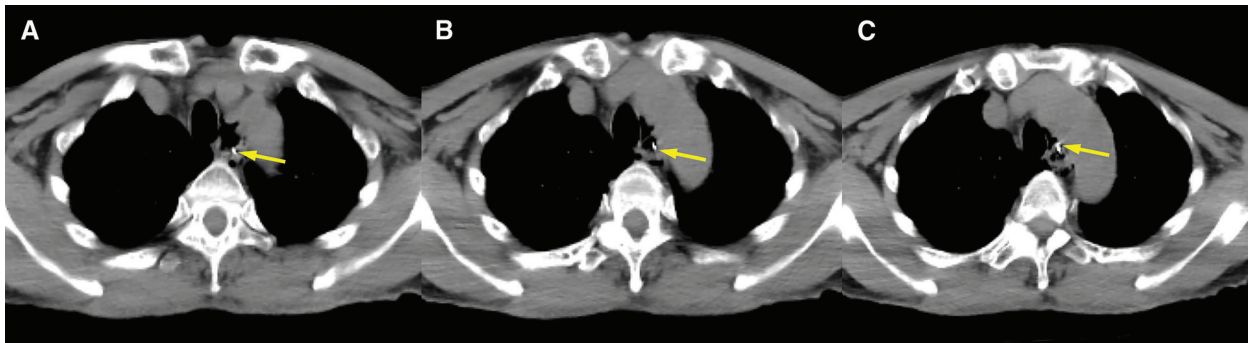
CT images in the local hospital showing the needle stuck in the dilated esophagus, meanwhile contributing to mild mediastinal emphysema. (A) The needle tail (arrow) penetrated the esophageal wall toward a left posterior direction, (B) the body of the needle (arrow) was still located in the esophagus, and (C) the needle tip (arrow) pierced through the esophageal anterior wall, causing localized edema of esophageal wall.
